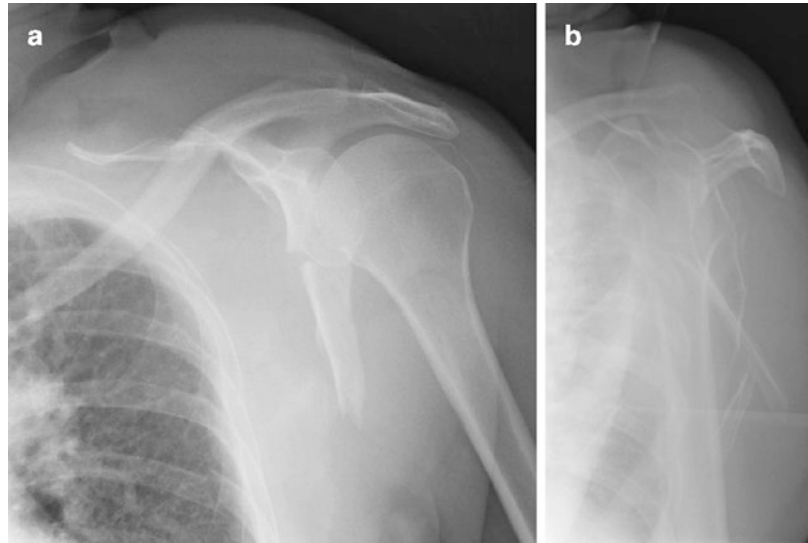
The angulation and “z” type deformity can be appreciated on the scapula Y radiograph
